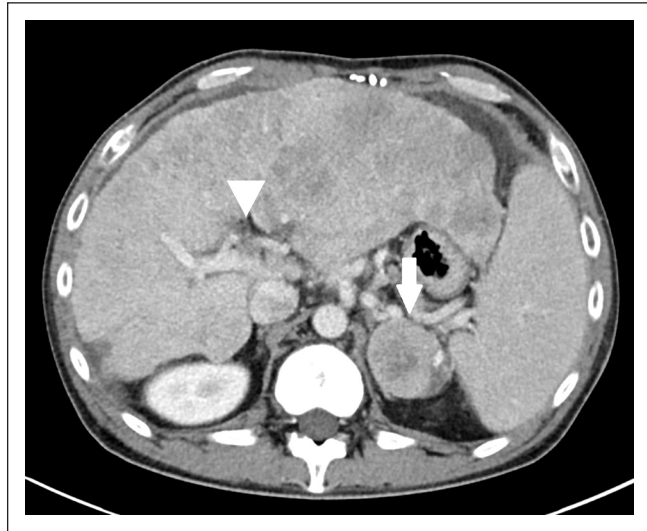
Enhanced CT imaging at the patient's first visit to our hospital. The results of CT showed a large hepatic tumor that occupied the liver, with left portal invasion (arrowhead) and metastasis of the left adrenal gland (arrow).
